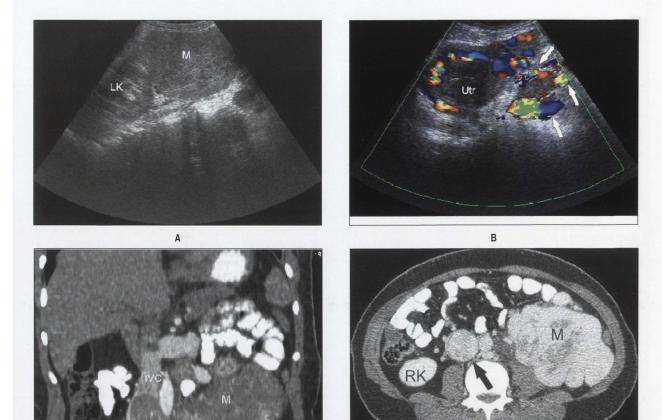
Solid nonnecrotic retroperitoneal leiomyosarcoma in a 38-year-old woman with left flank pain. Sonogram of the left lower quadrant shows a large echogenic mass adjacent to lower pole of the left kidney (A), myometrium is heterogenous and has an increased vascularity (B). Also, note the numerous pelvic collateralls (arrows). Contrast-enhanced CT scan obtained during arterial phase (C) shows intense heterogenous enhancement of a mass on sagittal reformatted images. The enhancing tumor thrombus partially occluding and expanding the IVC and the left iliac vein (arrow). Axial contrast-enhanced CT in the portal-venous phase (D) demonstrates enhancing tumor and tumor thrombus in the IVC (black arrow).
